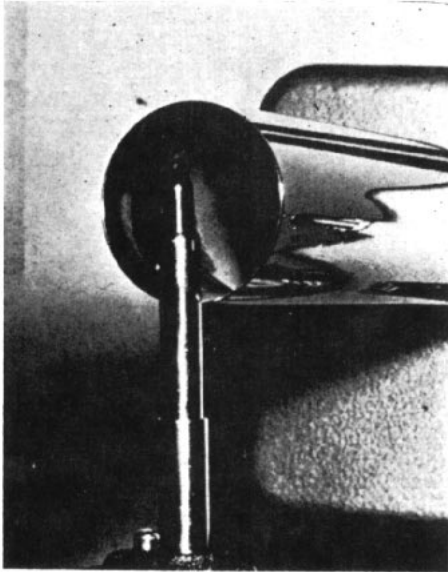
Glasser-Seitz Radiation Meter measuring primary ray intensity in roentgens at the end of cylinder.
